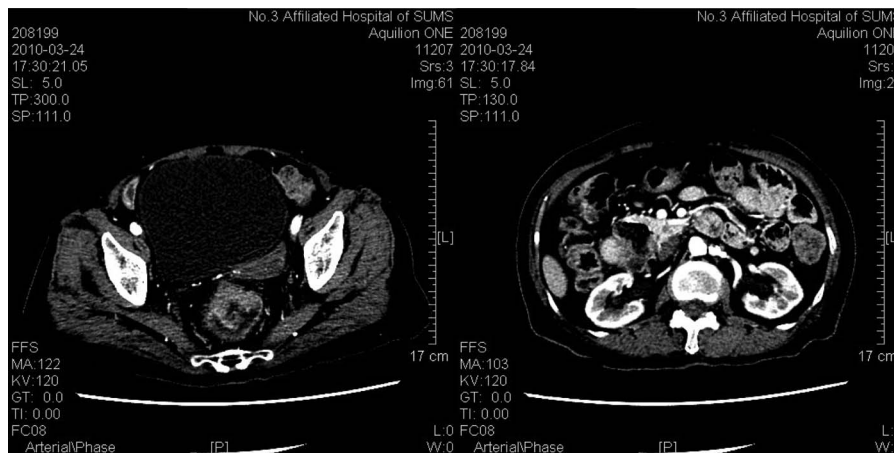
Rectal cancer and duodenal diverticulum presented by computed tomography scan.
